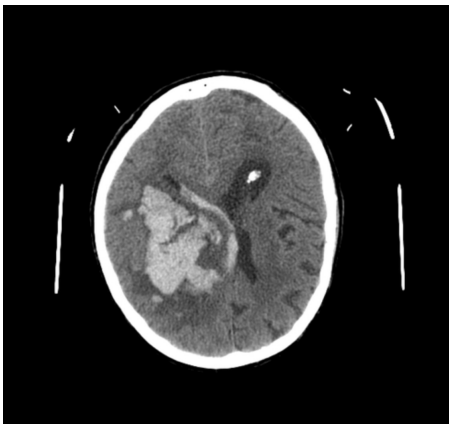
CT scan showing intracerebral hemorrhage. The image displays a large, irregular hemorrhage on the right side of the brain, measuring approximately 75 mm across. The bleeding involves the basal ganglia region and is accompanied by swelling and several smaller hemorrhages nearby (Radiopaedia.org (n.d.)).
